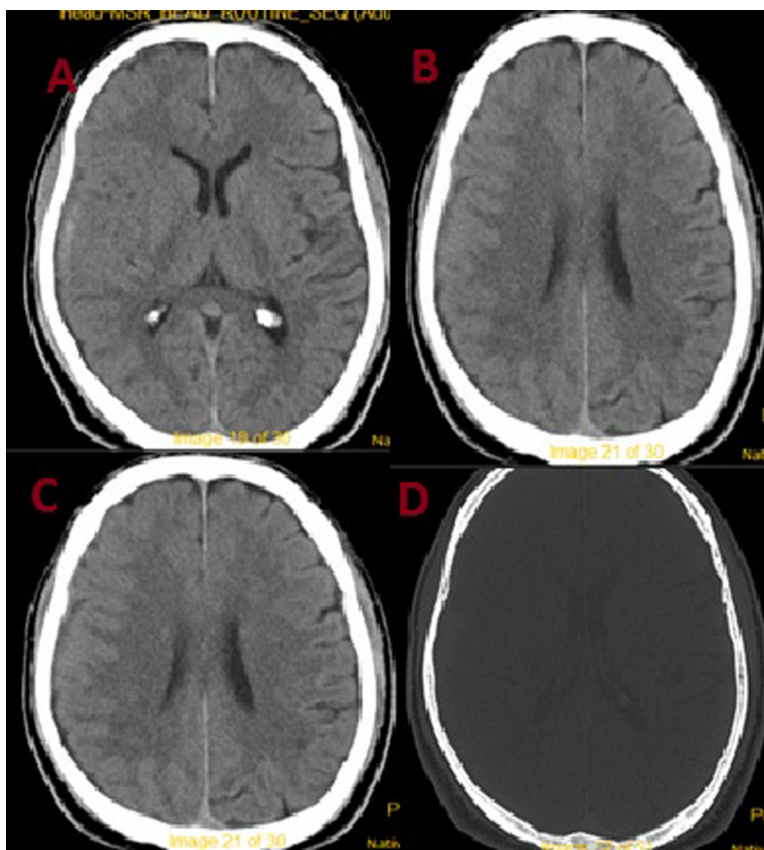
Repeated CT after a week. CT head plain axial view. (A–C) Resolving subdural hematoma and (D) intact calvaria on bone windows.
